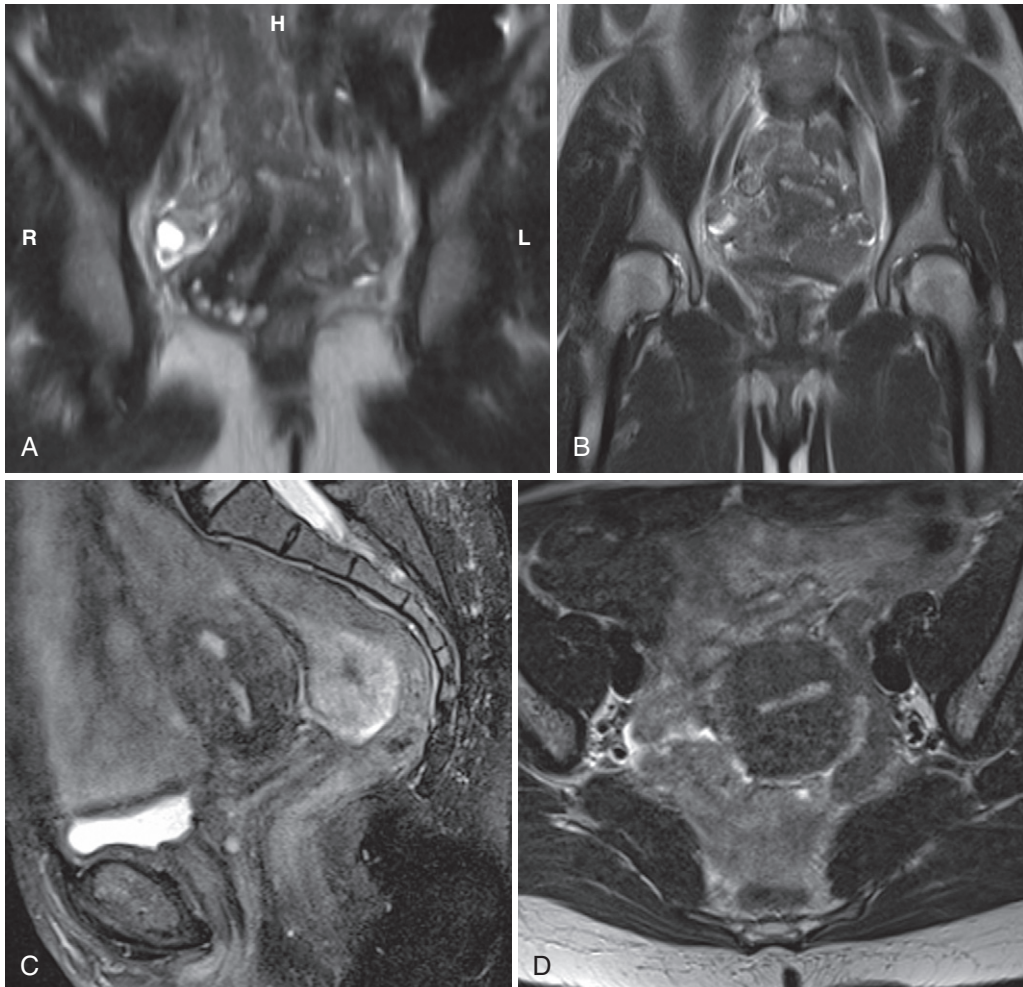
T-shaped uterus. A, Obliquely coronally reformatted T2-weighted image in a 47-year-old woman with a history of fetal diethylstilbestrol exposure elegantly portrays the aberrant anatomy that is less clearly rendered with coronal (B), sagittal (C), and axial (D) planes prescribed orthogonally to the axes of the body.
